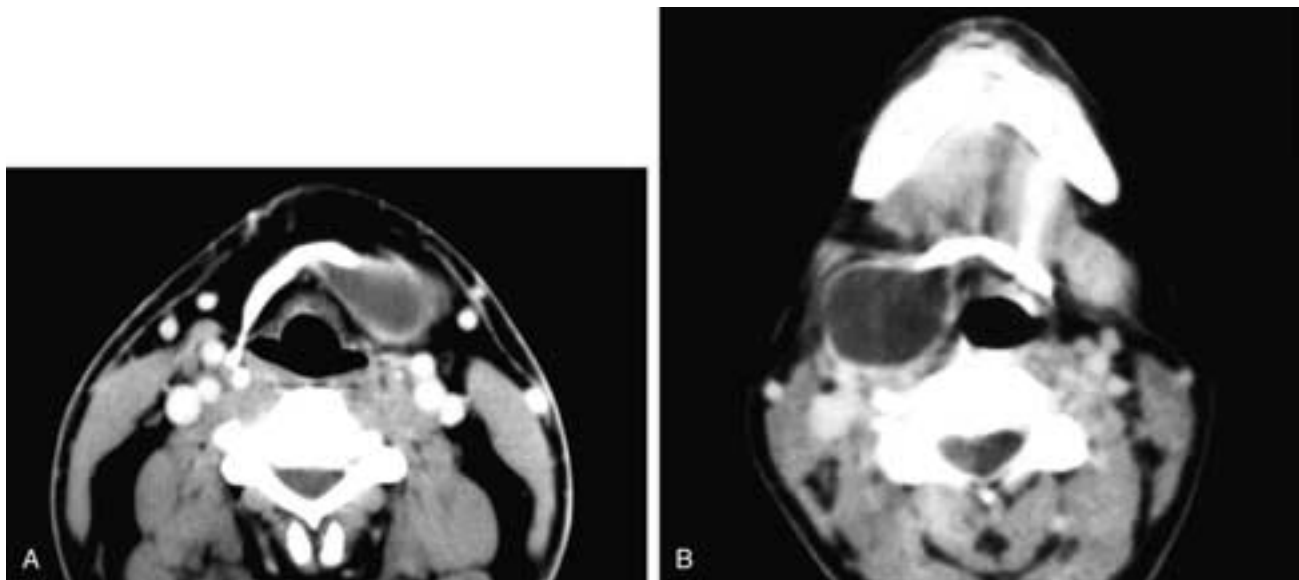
Axial contrast-enhanced CT scans on two different patients, each thought clinically to have a branchial cleft cyst. In A, a left-sided cyst “dives” into the hyoid bone. In B, a right-sided cyst “dives” into the hyoid bone. This finding establishes the diagnosis of thyroglossal duct cysts. Branchial cysts do not have such a relationship to the hyoid bone.
